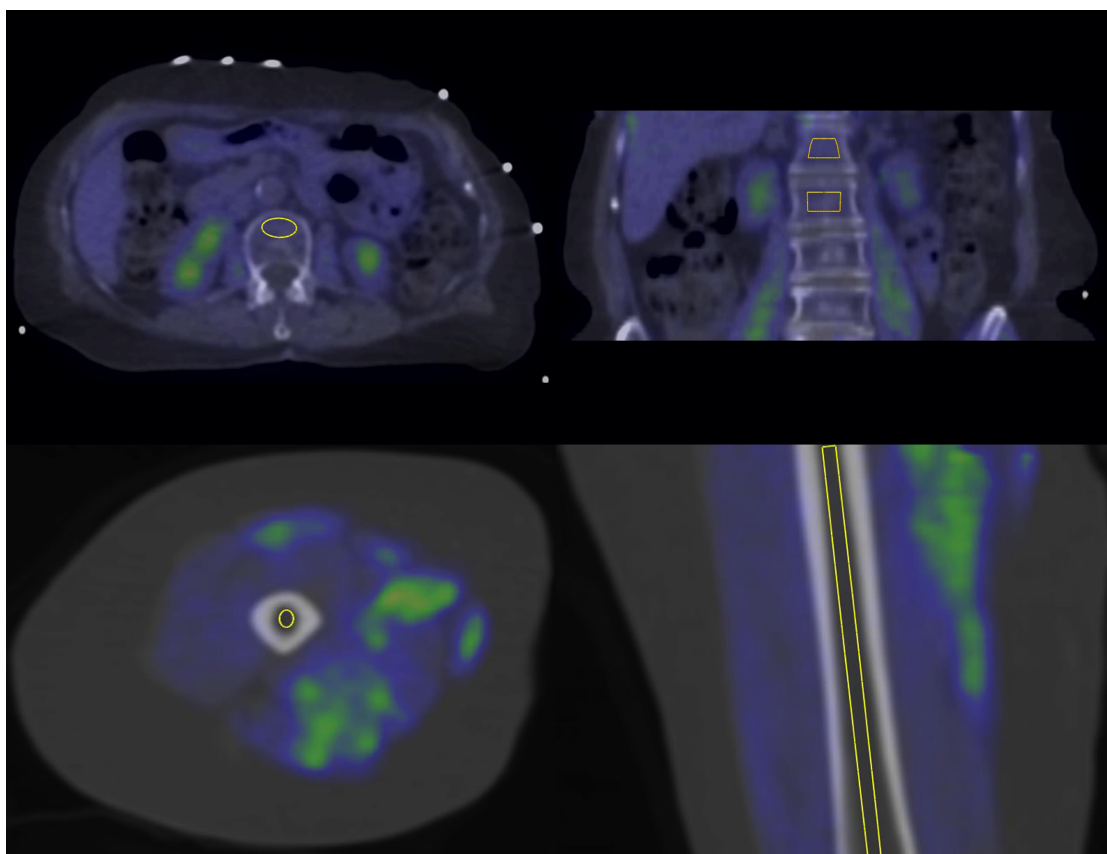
Volumes of interest drawn on vertebral bone marrow (upper row) and femoral bone marrow (lower row) in PET-CT images. Reprinted with permission from Study III.
